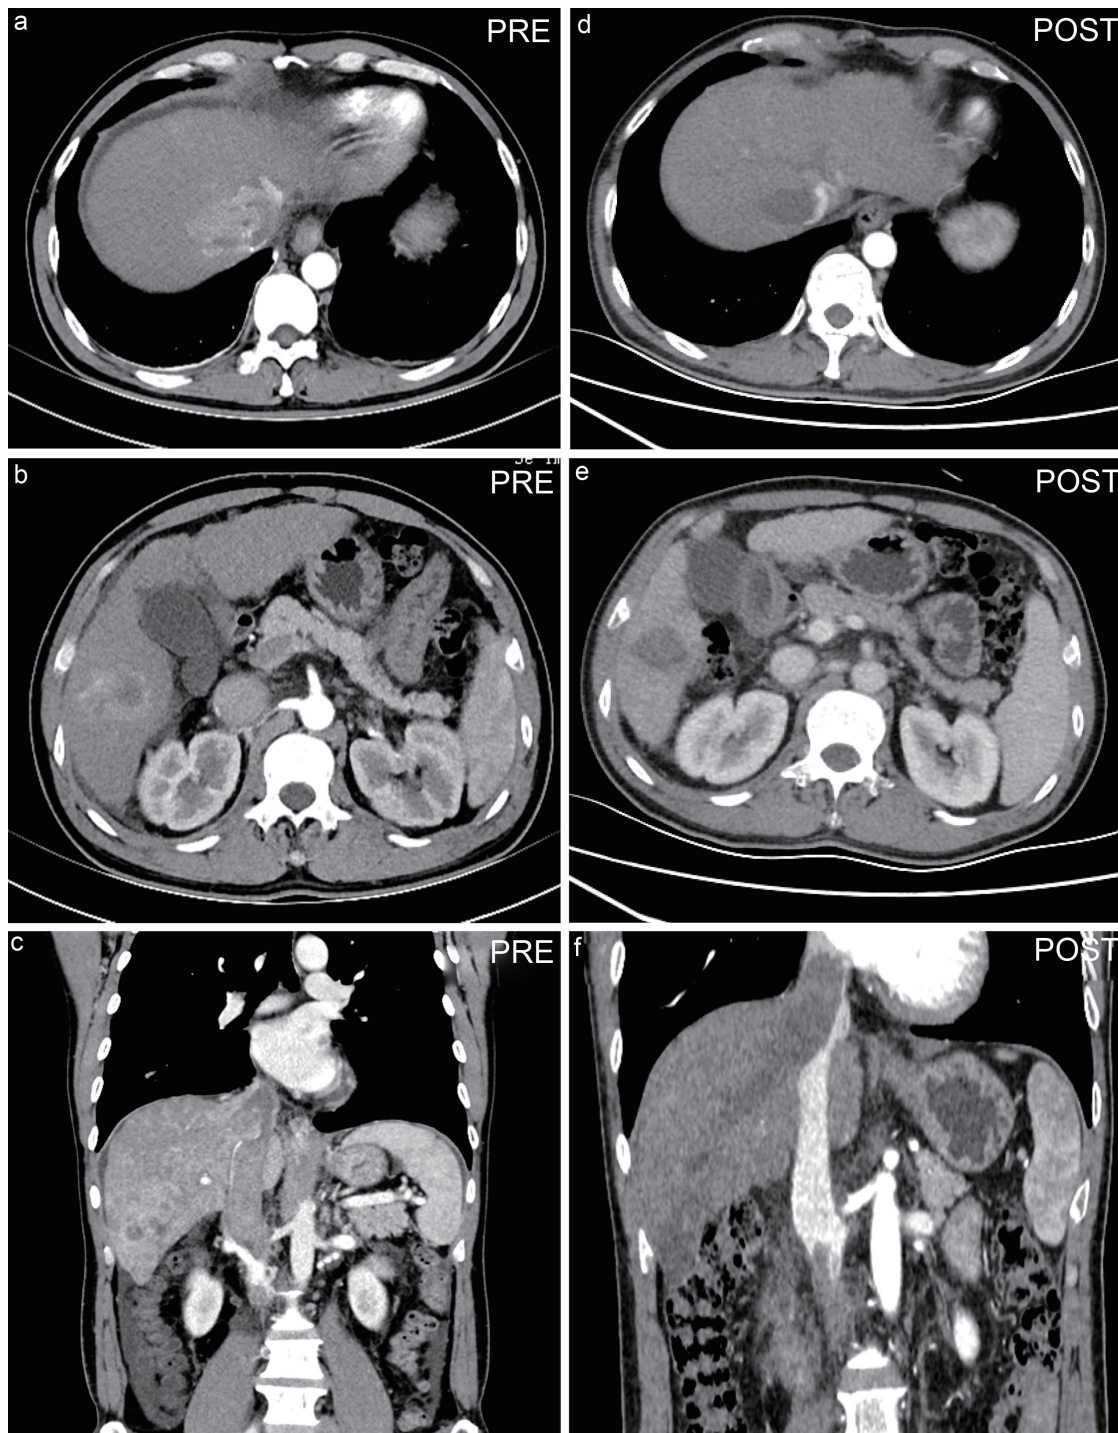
Preoperative and 3-month postoperative CT images. Contrast-enhanced CT revealing multiple nodules in the right liver lobe in the arterial phase, moderate enhancement in the arterial phase, and filling of low-density shadows in the inferior vena cava and hepatic vein in the coronal plane (a, b, c). At 3 months after DEB-TACE, CT showed no enhancement of the liver cancer lesions and tumor thrombus, and the thrombus disappeared (d, e, f). CT, computed tomography; DEB-TACE, drug-eluting beads transarterial chemoembolization.
